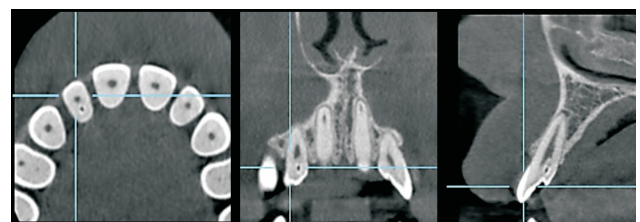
CBCT images of tooth #12-Axial, Coronal, Sagittal view
